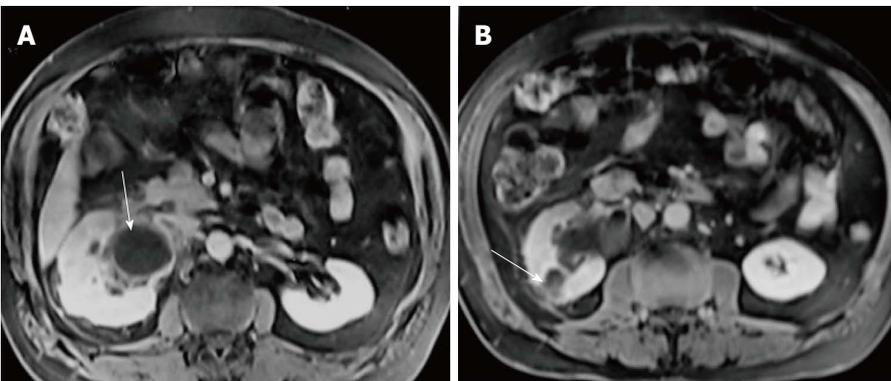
Axial sections of post gadolinium magnetic resonance imaging. A 42 years old male with right hydronephrosis, peripheral enhancement of dilated pelvis (arrow, A) representing pyonephrosis along with a heterogeneously enhancing focal lesion in right kidney (arrow, B) suggestive of focal pyelonephritis.
